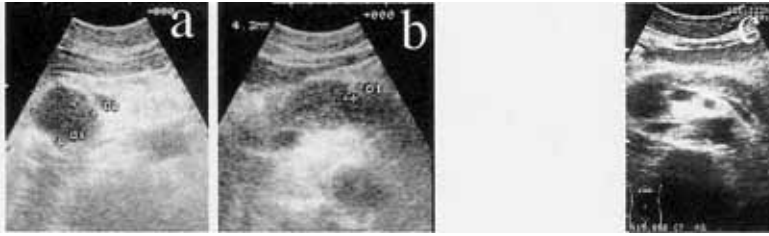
a,b: Ultrasonography images on the first admission, showing sausage-like enlargement of the pancreas. Particularly, the head of the pancreas seemed like a mass. c: Ultrasonography image after starting steroid therapy revealing improvement of enlargement of the pancreas.
